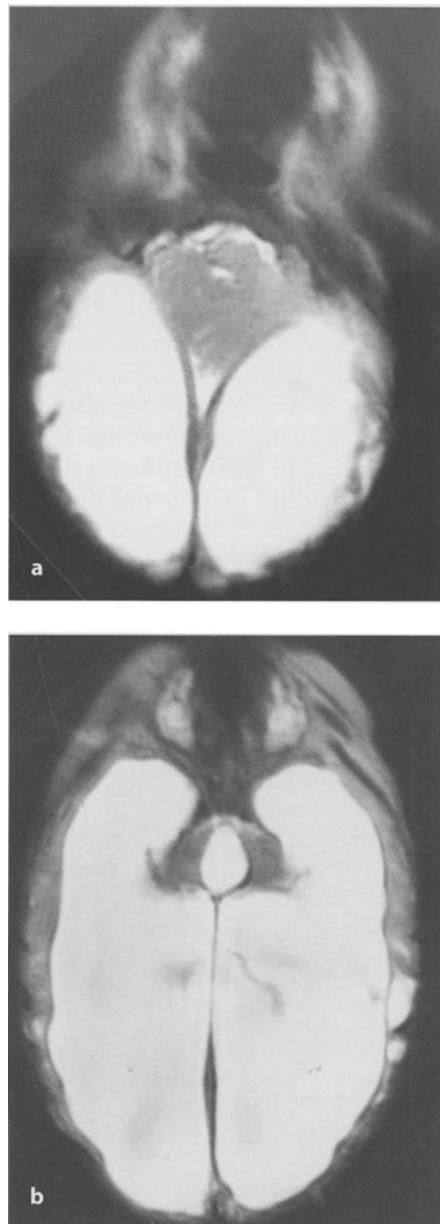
Neuroimaging of a 1-month-old girl born with thoracic myelomeningocele and hydrocephalus. The initial decision was against active treatment, as she was considered to be too severely affected and it was believed that she would not survive. Having survived for 1 month, she was subsequently offered surgical treatment. a Axial T2-weighted MRI scan showing a very small fourth ventricle, grossly dilated lateral ventricles and very thin cortical mantle. b Axial T2-weighted MRI scan showing a dilated third ventricle and lateral ventricles with very attenuated cortical mantle. These appearances strongly suggest severe aqueduct stenosis
